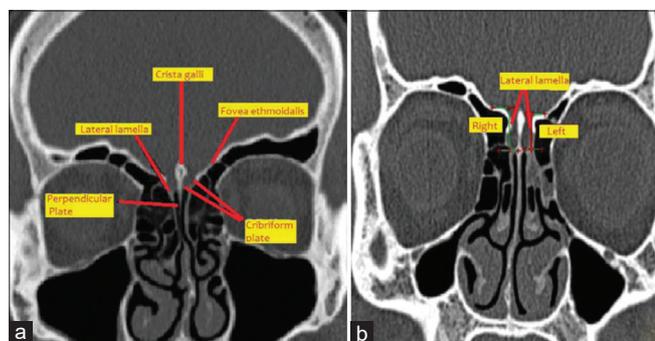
Reformatted coronal computed tomography scan showing: (a) Normal anatomy, (b) Lateral lamella utilized to measure olfactory fossa depth
